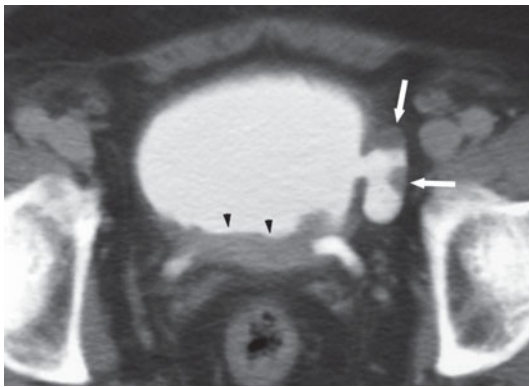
Computed tomography. Bladder cancer. In the late phase of the dynamic study a diverticulum with a narrow neck can be visualized. Filling defects with their base attached to the wall of the diverticulum itself are present (*arrows*). Nonuniform thickening of the posterior bladder wall is also visible (*arrowheads*)
